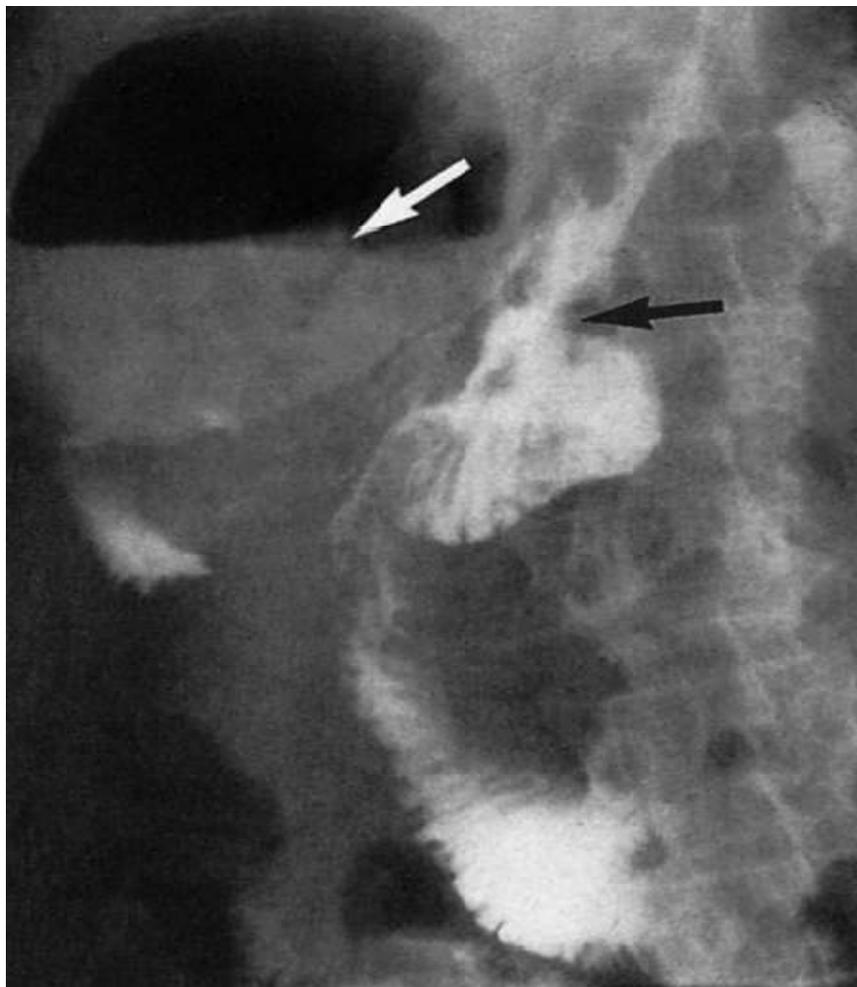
14 Plain radiograph showing subphrenic abscess
